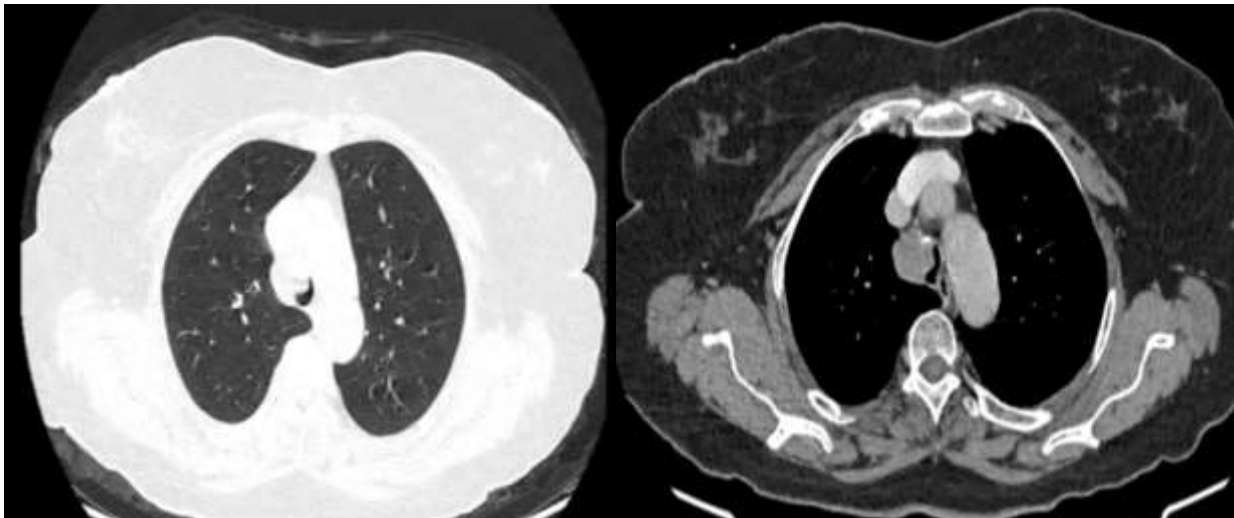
(A, B): Chest CT Scans in parenchymal window A and mediastinal window B) showing thickening of the right lateral wall of the trachea responsible for stenosis.
